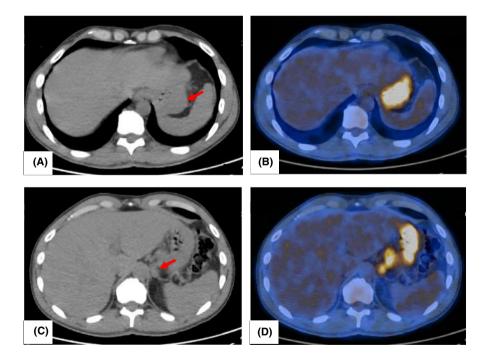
Intense contrast uptake diffusely involving the gastric body and fundus (A), and hypermetabolic adenopathies in the hepato-gastric ligament (C), shown in contrast-enhanced CT, with high metabolic activity on PET/CT (B, D), performed in 2022.
